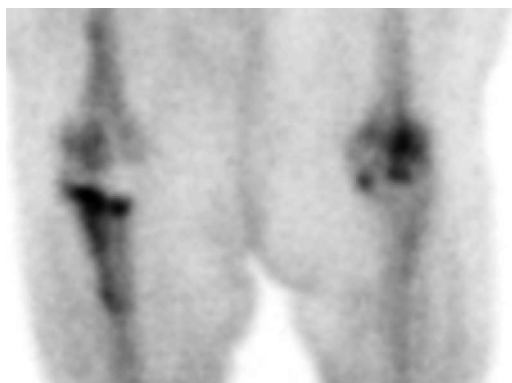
Asymptomatic right knee arthroplasty. On the ^{99m}Tc -MDP bone scan, there is irregular, intense radiopharmaceutical accumulation around the long stemmed tibial component of a three year old right knee replacement. The femoral component is unremarkable. The patient had a history of breast carcinoma and bone scintigraphy was performed as part of a routine evaluation for metastatic disease.
